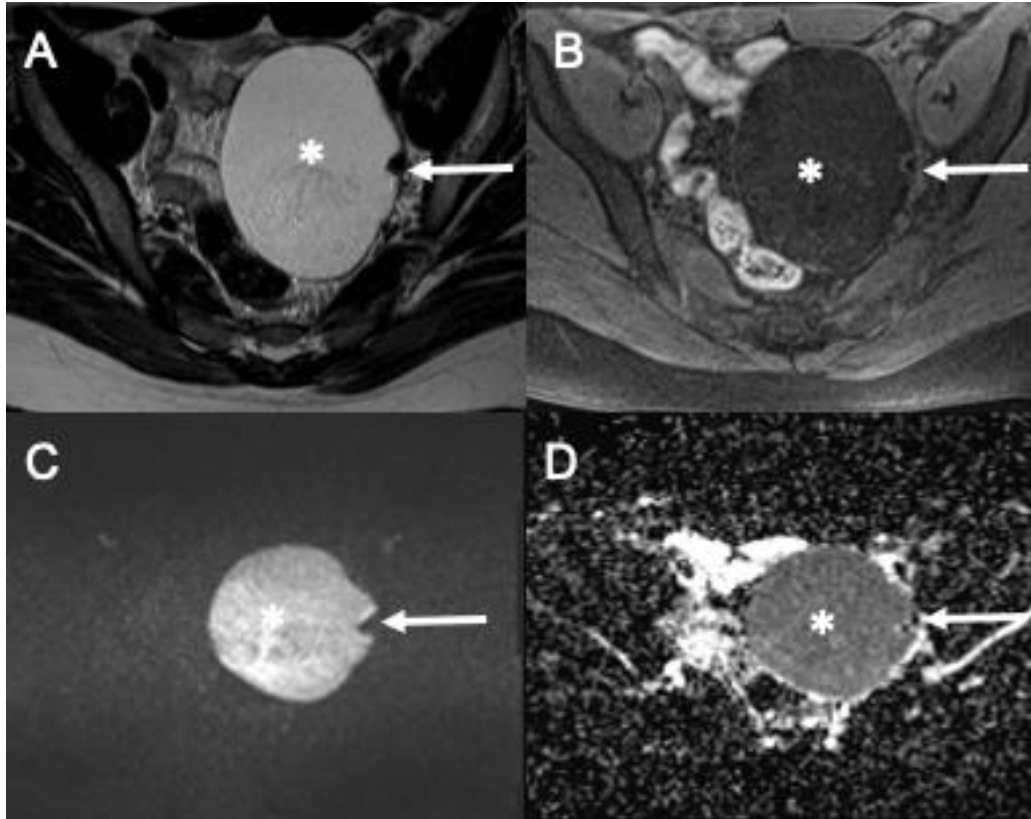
MRI of MCT with mild restricted diffusion. MRI shows a unilocular cystic lesion with a hyperintense signal on T2-weighted image (A) but a loss of signal on T1-fat suppression (B) corresponding to fat tissue (asterisks). The lesion demonstrates mild restricted diffusion (C: diffusion, B value: 1000 sec/mm³; D: attenuation diffusion coefficient) without implying cellularity. A nodule is noted, which is hypointense both on T2 (A) and T1-fat suppression (B), and does not have restricted diffusion (C, D) and corresponds to the Rokitansky nodule (long arrow).
